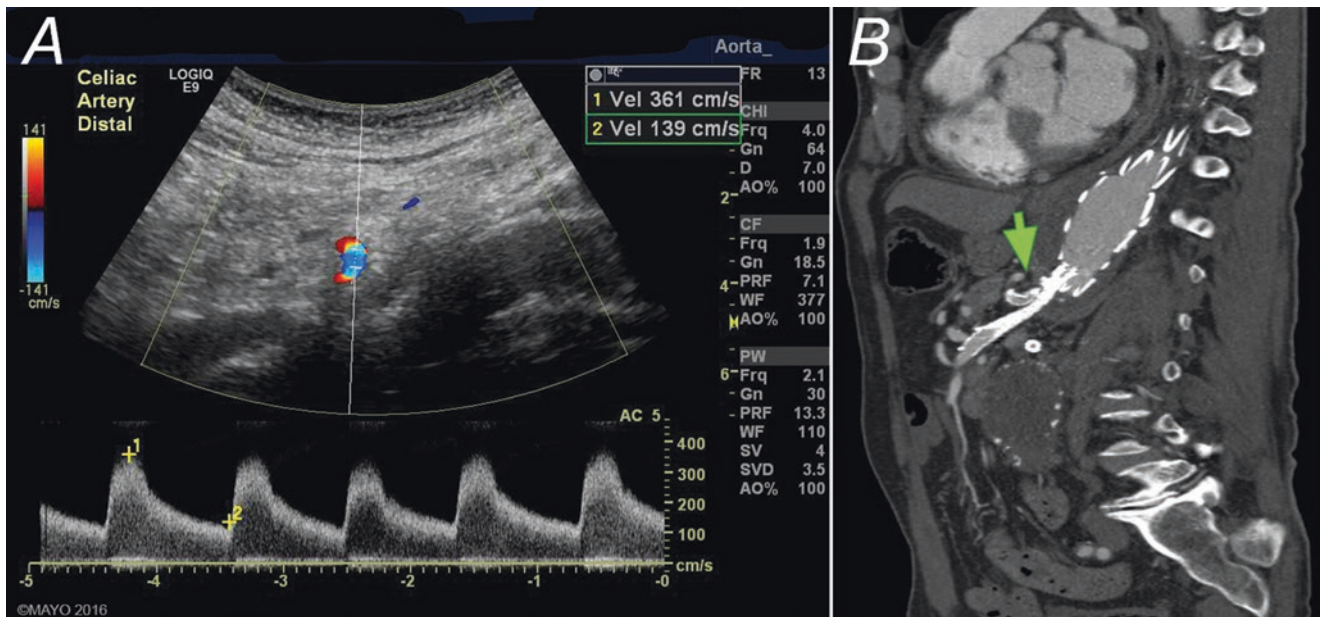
Duplex ultrasound and computed tomography angiography (CTA) of fenestrated endograft with a celiac artery stent. Spectral Doppler demonstrates elevated peak systolic velocity of 361 cm/s associated with turbulence and color aliasing (a). In our experience, elevated velocity greater than 270 cm/s is indicative of 50% or greater stenosis. Correlation with CTA in sagittal view confirmed stent kink and luminal narrowing (arrow) at the site of high velocities (b). By permission of Mayo Foundation for Medical Education and Research. All rights reserved
